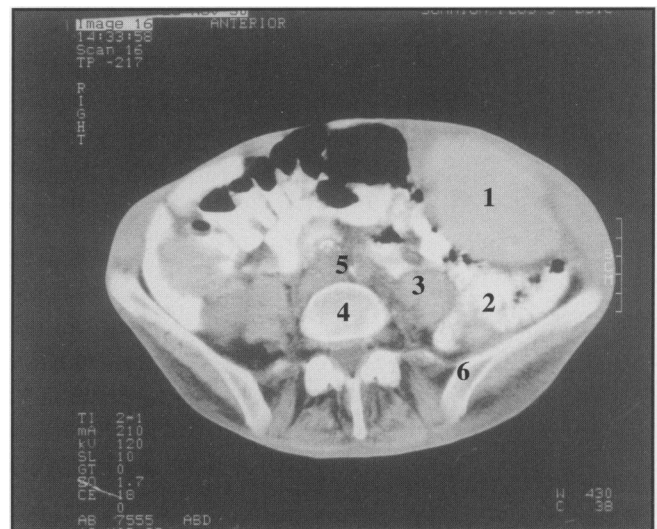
CT scan of abdomen showing:
